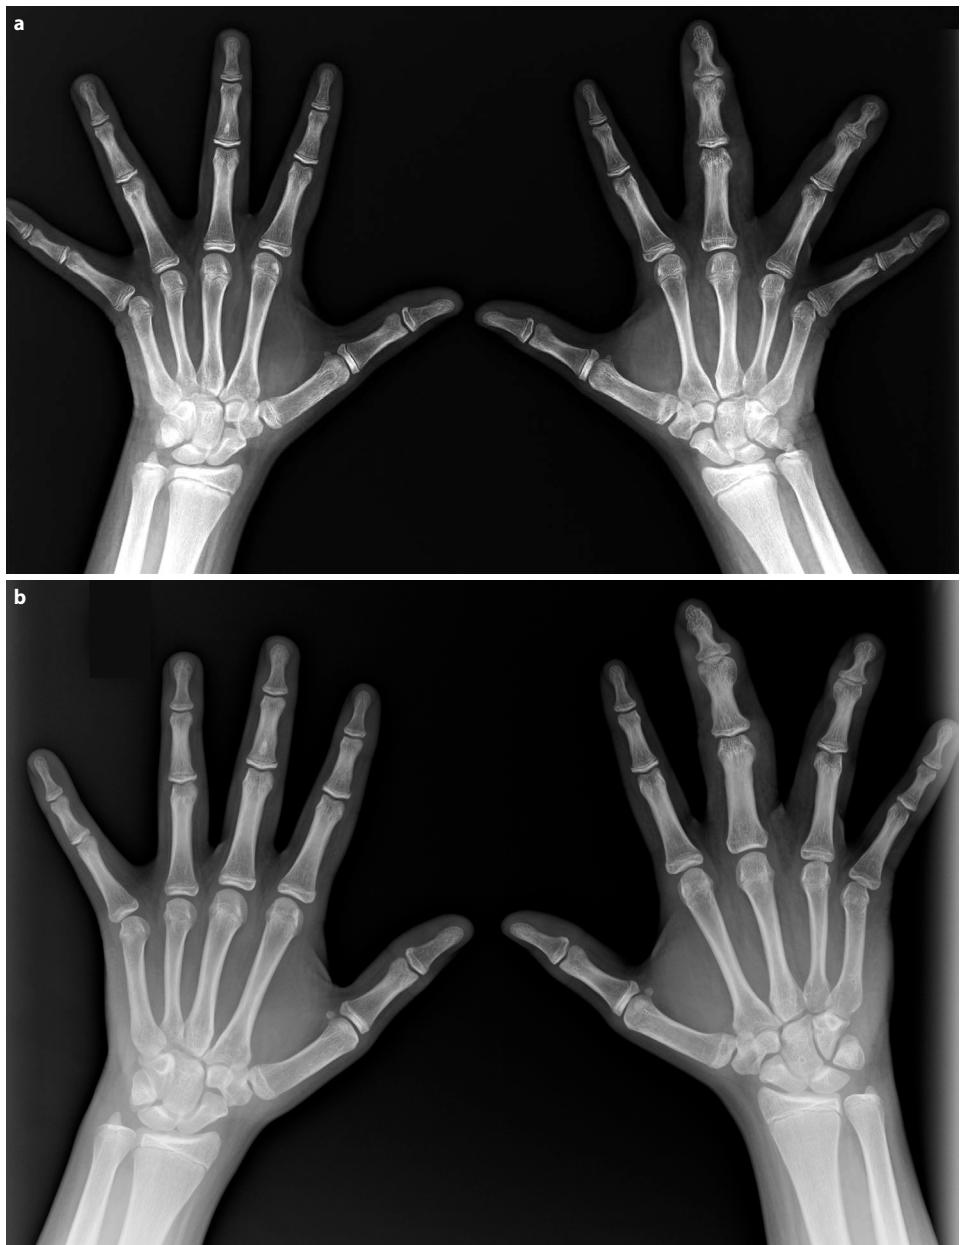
Result of surgical treatment: X-ray a 13 years 1m, b 14 years 3 m.
